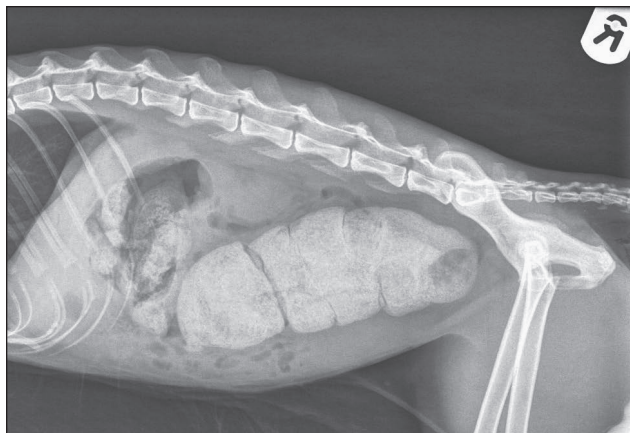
Pre-operative radiograph demonstrating megacolon.
